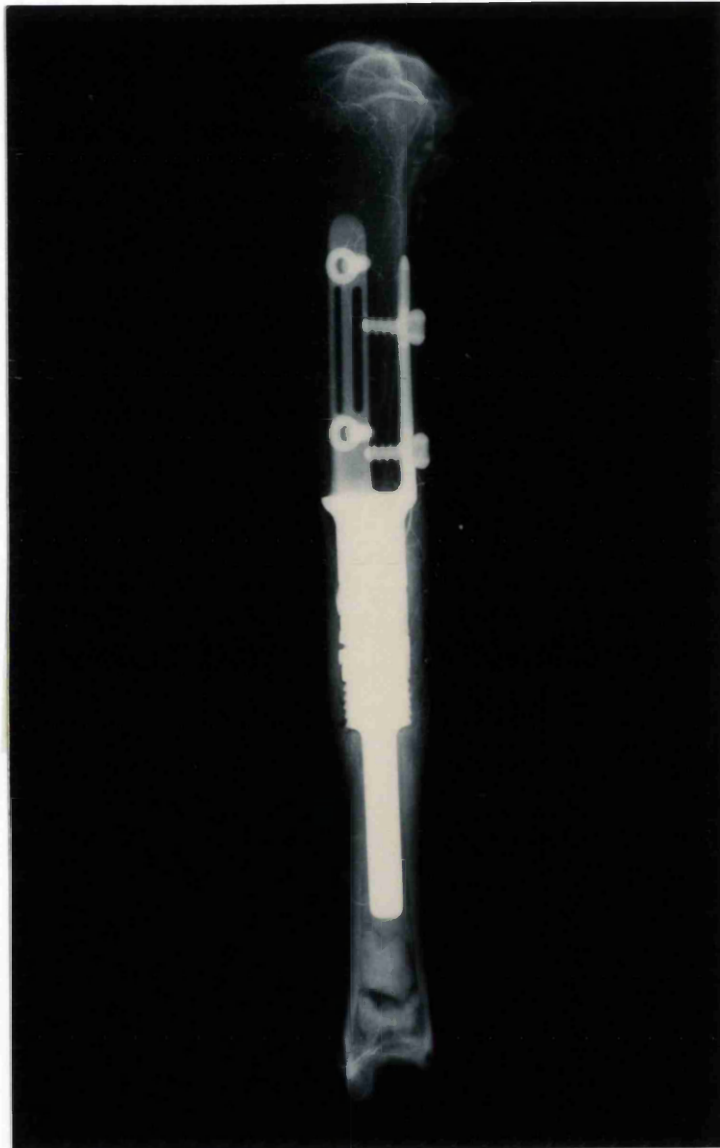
A radiograph of a two plated prosthesis retrieved 6 months after surgery.
